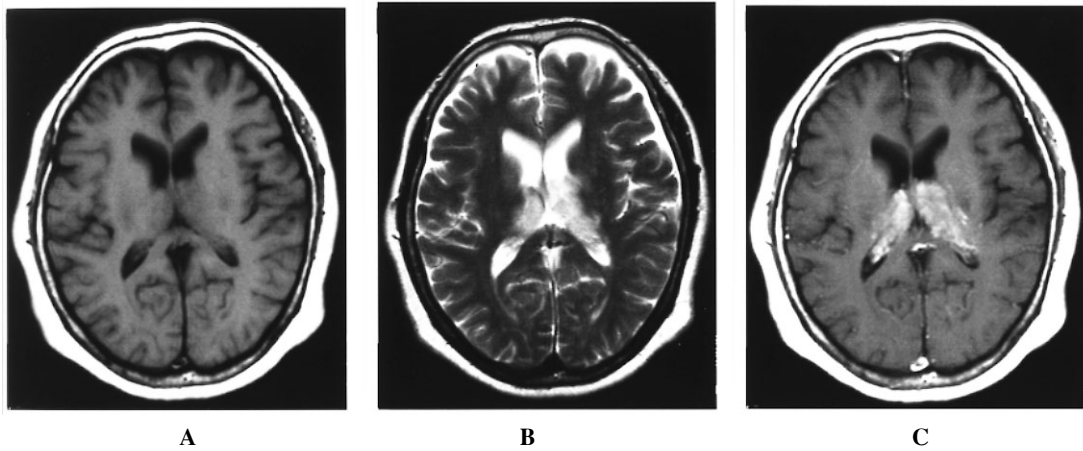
A: Axial unenhanced T1-weighted MR image showing slightly hypointense areas in the bilateral thalamic region. B: Axial T2-weighted image demonstrating areas of distinct hyperintensity in the bilateral thalami. C: Axial gadolinium-diethylene triamine pentaacetic acid (Gd-DTPA) enhanced T1-weighted image showing heterogenous enhancement in the bilateral thalami.
